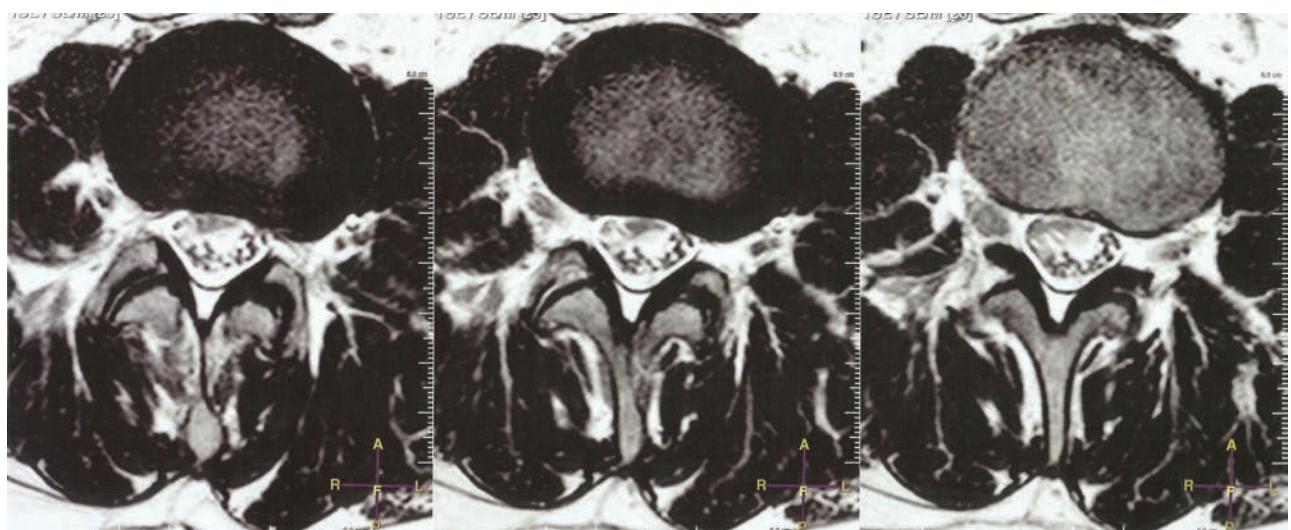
Axial T2-weighted lumbosacral magnetic resonance imaging showing an intradural extramedullary expansive lesion glancing to the L3-L4 right foramen.
